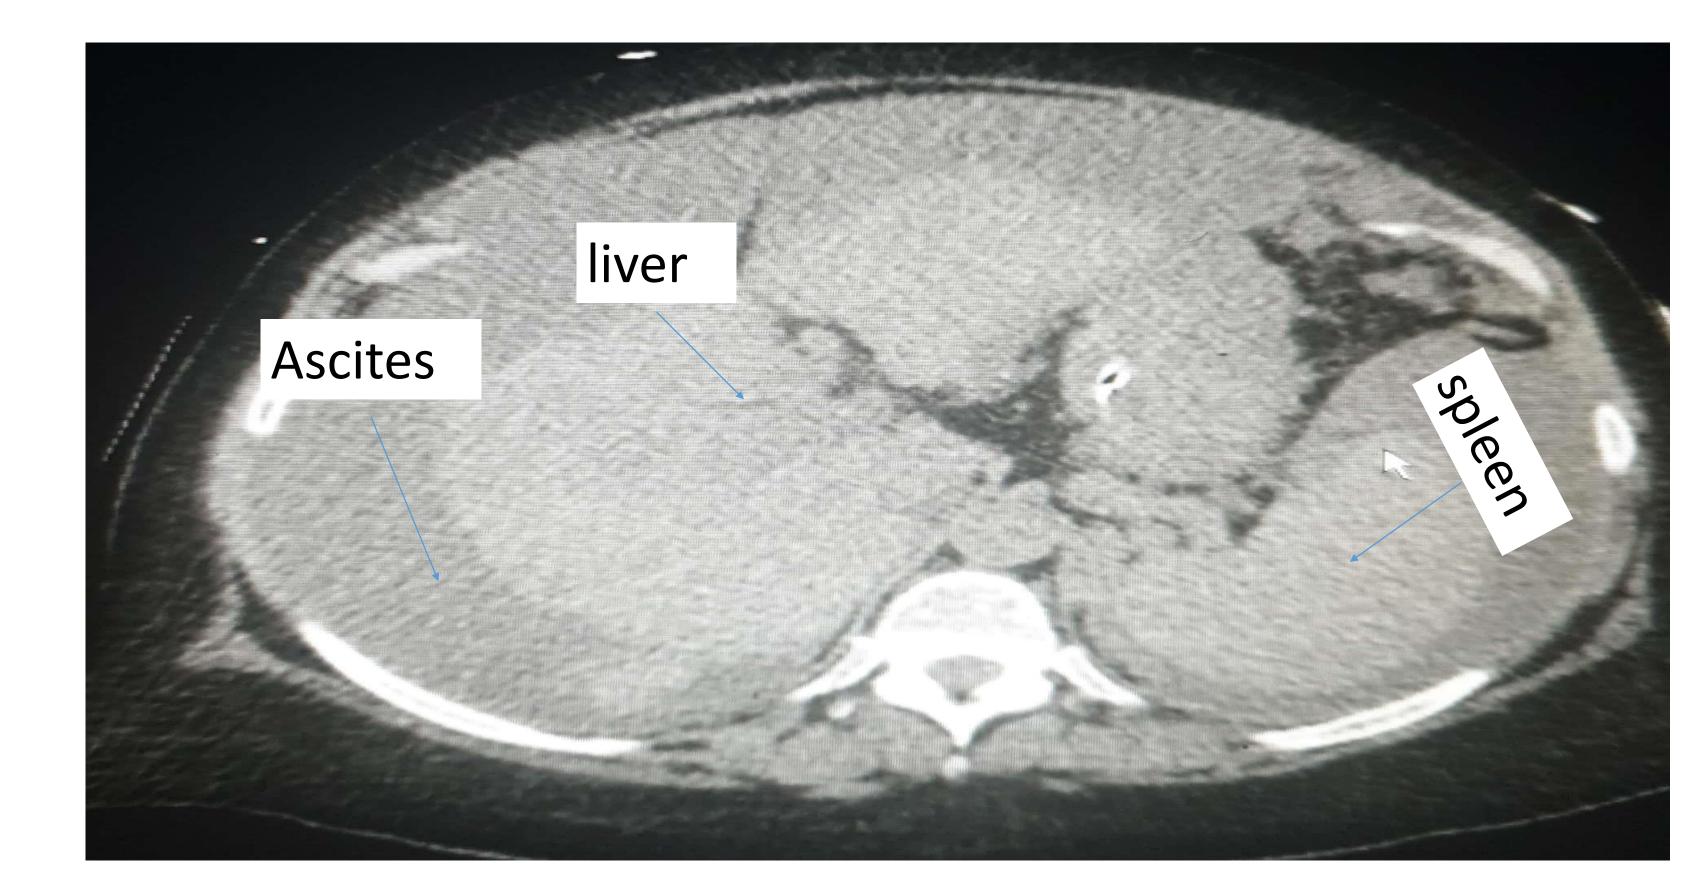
CT abdomen showing cirrhotic liver with no defined hepatic mass.
